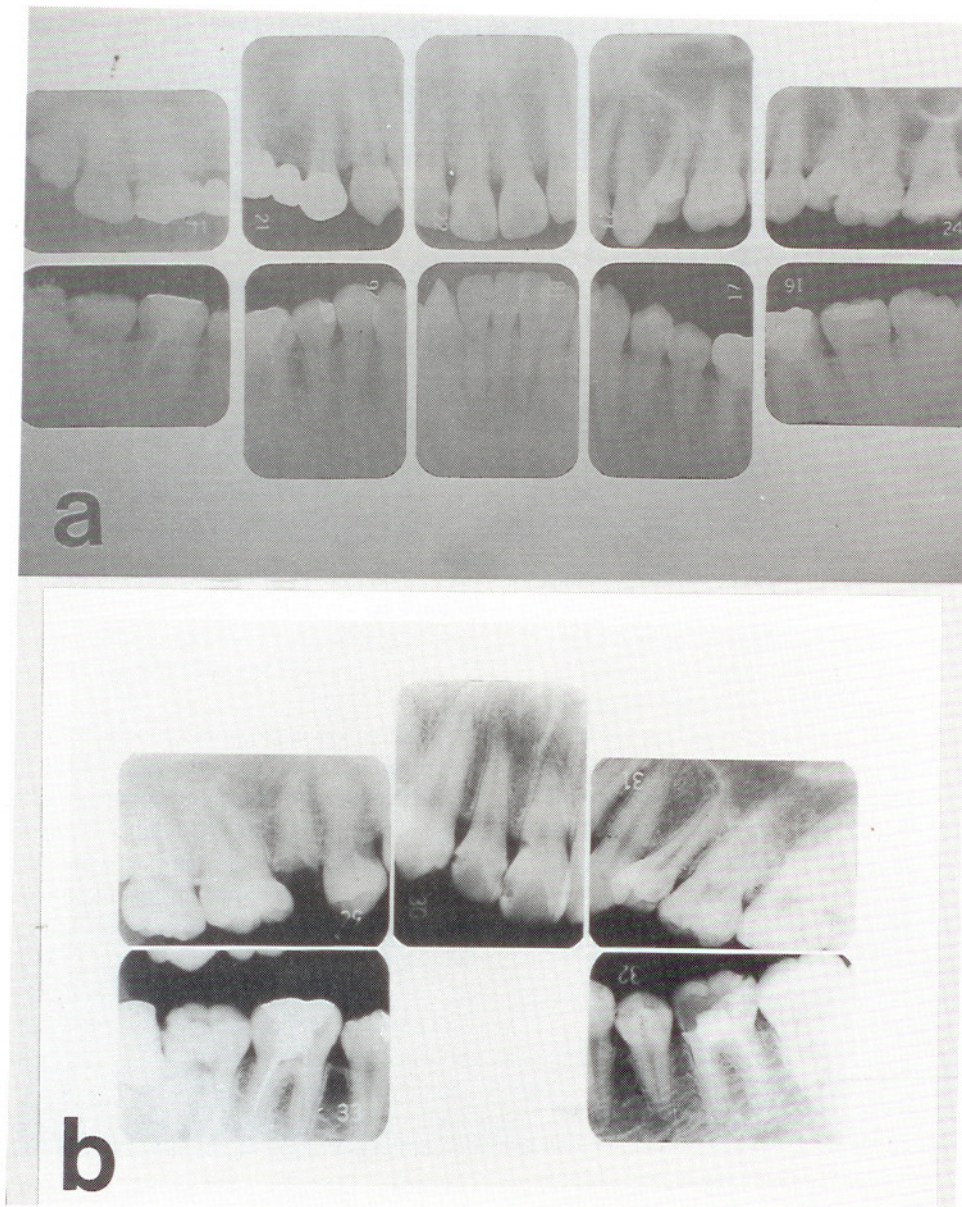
Radiographic comparison of (a) postmortem intro-oral dental radiographs of Victim C with (b) the antemortem ones.
